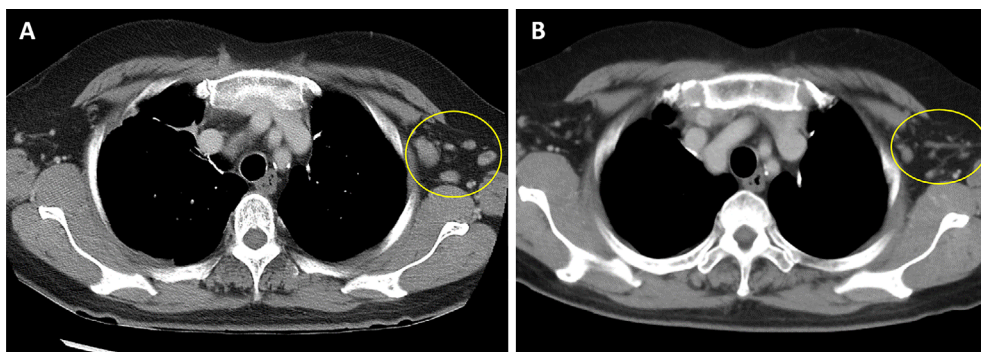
Images of Patient 3. (A) CT performed 14 days after the second vaccination showed enlarged lymph nodes in the left axilla (yellow circle). (B) CT performed four months after the vaccination showed that the lymph nodes had shrunk (yellow circle).
